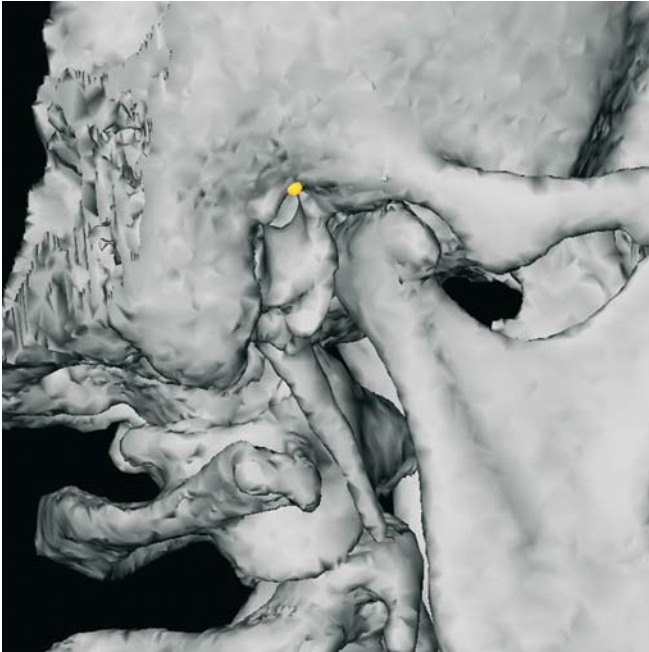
Porion_r. Profile view right (3-D CT, patient K.C.)
